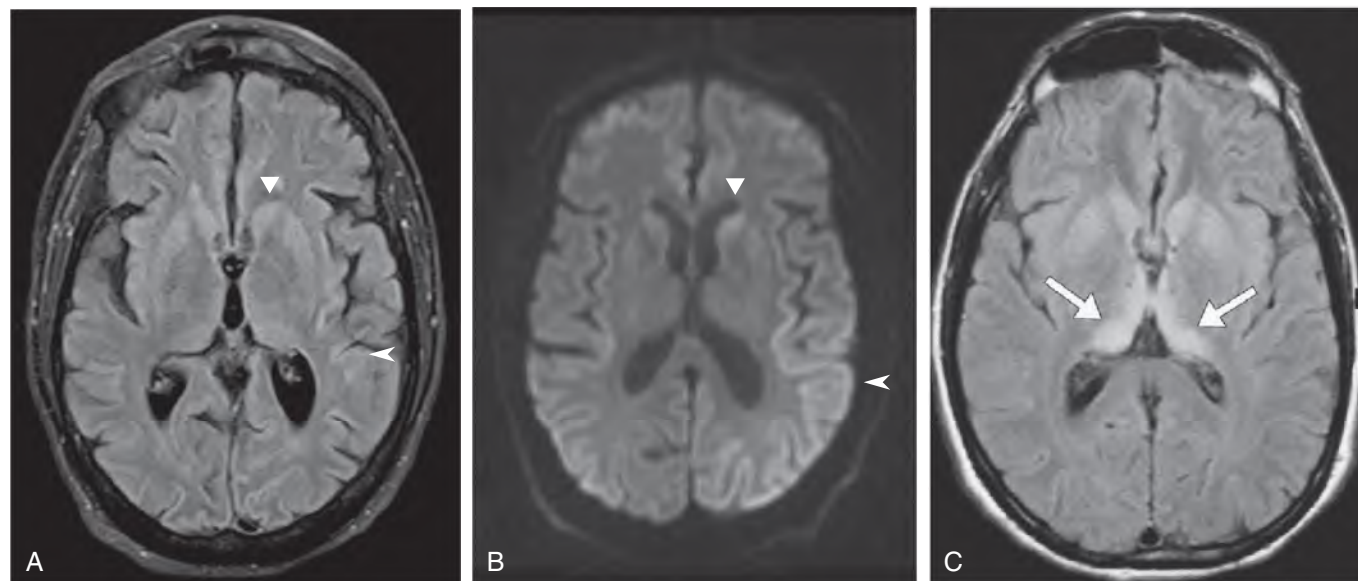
The magnetic resonance imaging appearance of prion disease. (A and B) Fluid-attenuated inversion recovery (FLAIR) image (A) and diffusion-weighted image (DWI) (B) from a 63-year-old man with sporadic Creutzfeldt-Jakob disease (CJD). There is subtle hyperintensity in the cortical ribbon (arrowheads) and head of the caudate (triangles), seen more clearly on DWI than on FLAIR. (C) FLAIR image from a patient with variant CJD displays hyperintensity in the posterior thalamus (arrows), the so-called pulvinar sign that is characteristic of this form of CJD. (C, From Tschampa HJ, Zerr I, Urbach H. Radiological assessment of Creutzfeldt-Jakob disease. *Eur Radiol.* 2007;17:1200–1211.)
